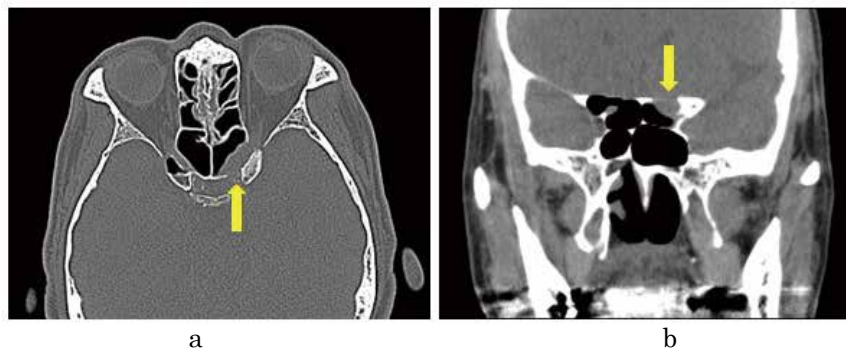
Axial CT scan (a) showing a mass of soft tissue density along the left optic canal extending to the left posterior ethmoid sinus and the cavernous sinus (arrow). Coronal CT scan (b) showing bony destruction between the optic canal and the skull base (arrow).
